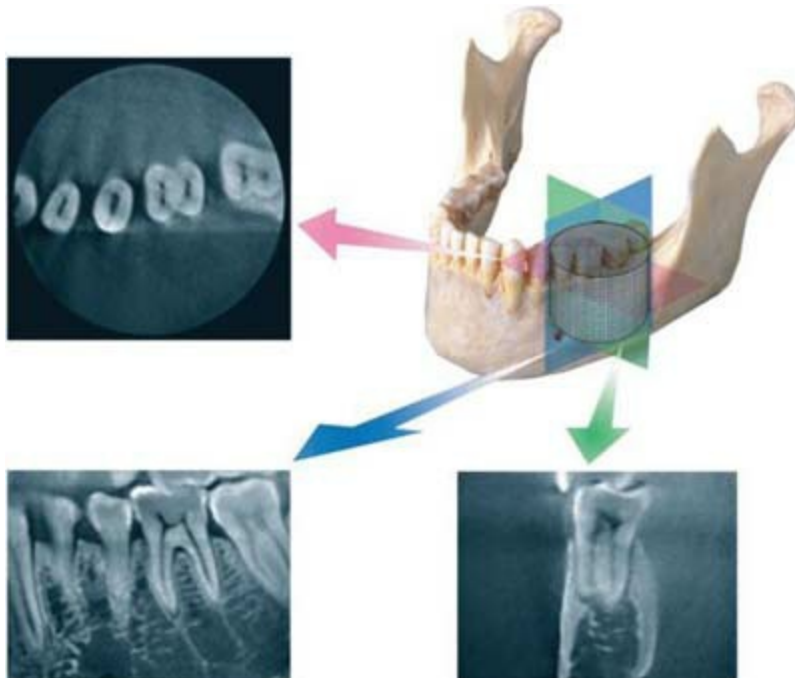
Cone-beam volumetric tomography has the advantage of being able to detect pathosis in the bone or associated with the teeth without the obstruction of anatomic structures. The planes of vision may be axial, sagittal, or coronal.
